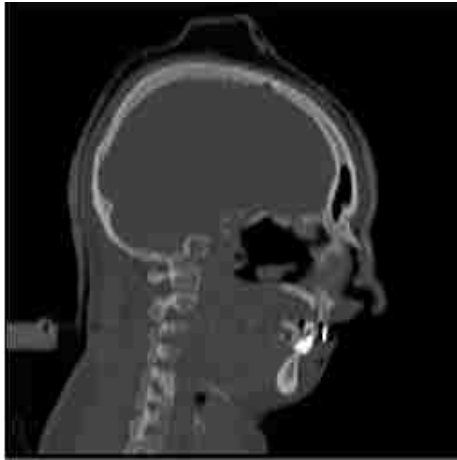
Lateral cut (CT scan) of a human head.
